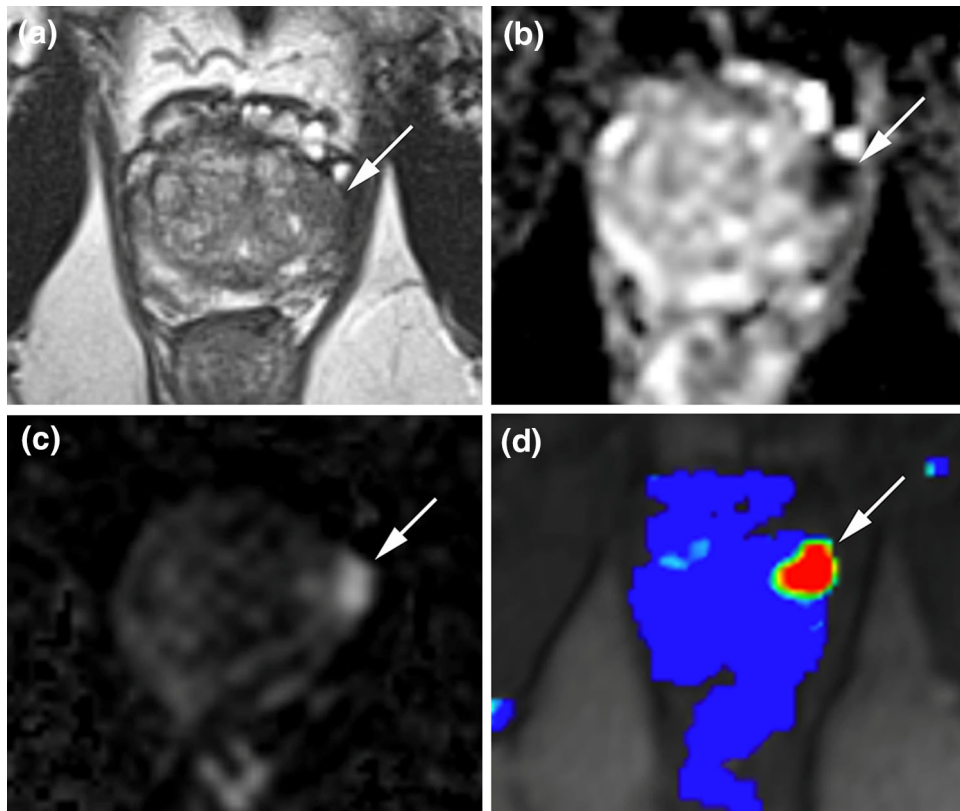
A 72-year-old male was referred for multiparametric prostate MRI (mpMRI). a Axial T2W image shows a mass-like area of decreased T2 signal intensity within the left anterolateral peripheral zone (*white arrow*). b Axial ADC map shows corresponding area of substantially low ADC, suggesting a higher-grade tumor (*white arrow*). c Calculated diffusion-weighted image at b -value of $1,500 \text{ s/mm}^2$ shows this area to have increased signal (*white arrow*). d Colorized washout map created using post-processing software
